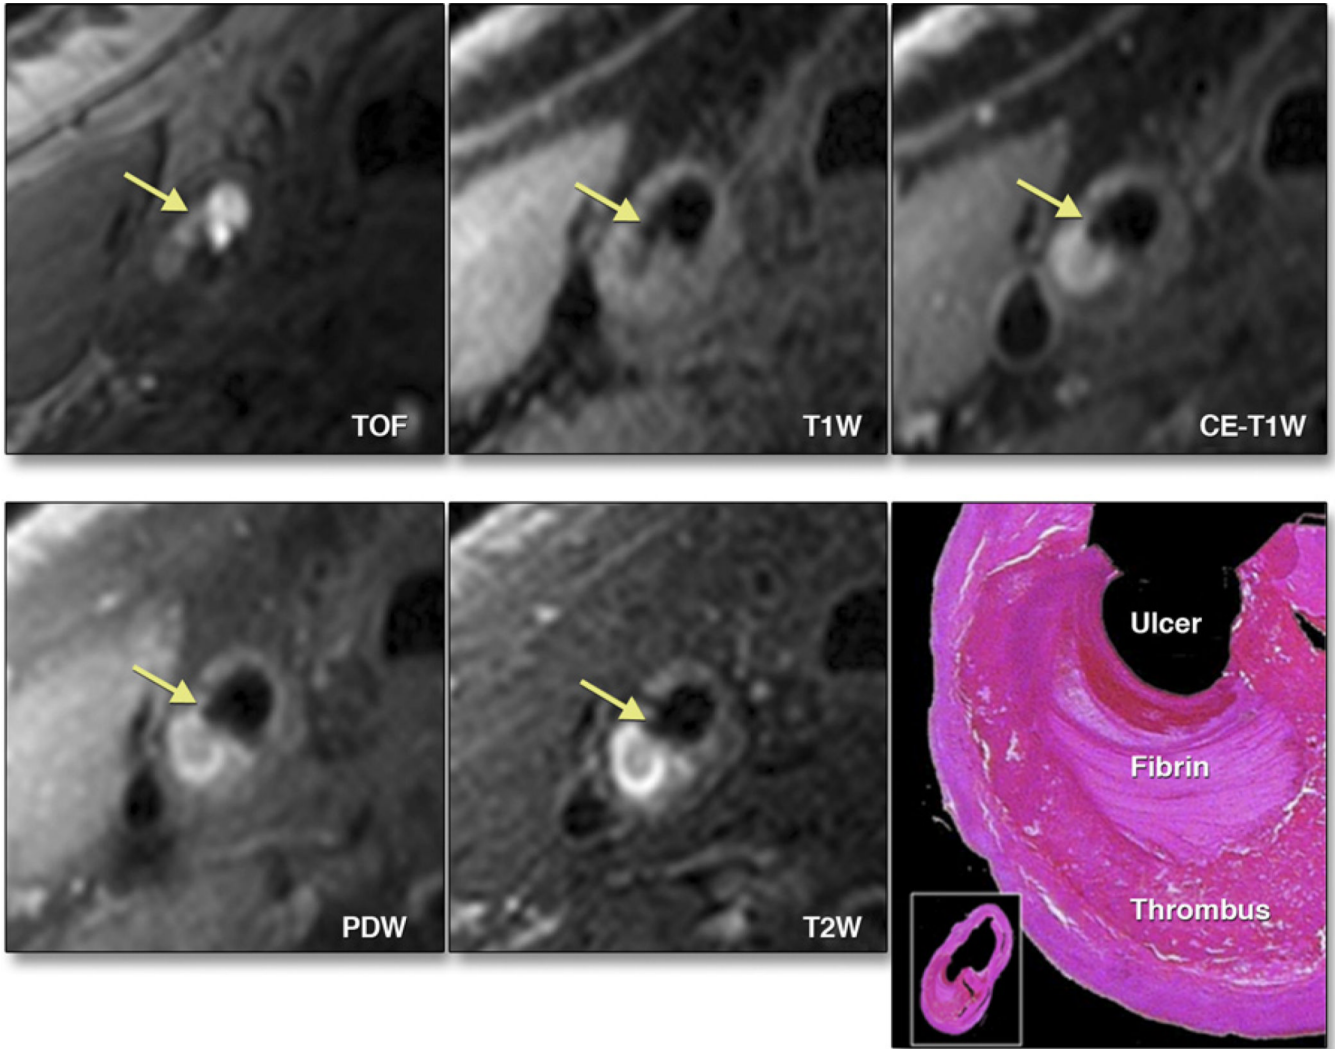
Morphological Characteristics of Carotid Artery Atherosclerosis Using MRI
